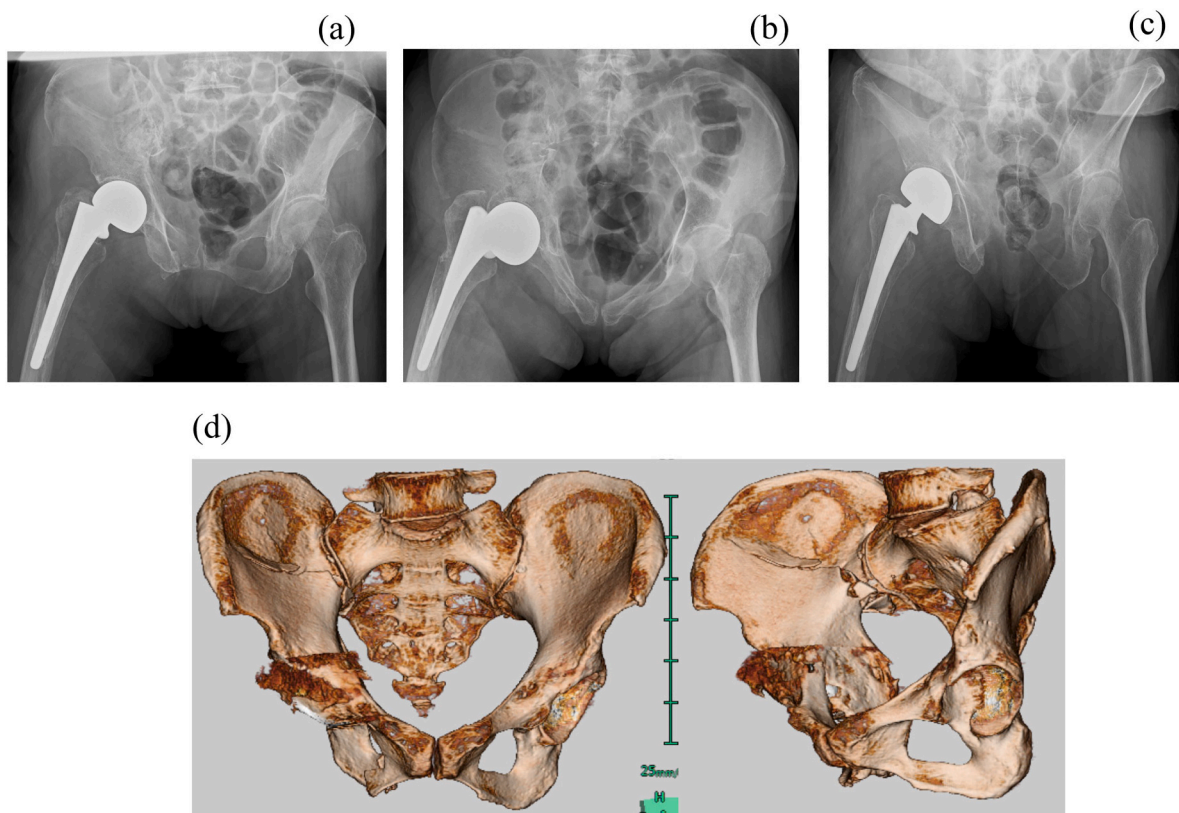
Representative pre-operative X-ray images taken during admission for fragility fracture of the pelvic ring. (a) Pre-operative pelvic anteroposterior view. (b) Pre-operative pelvic inlet view. (c) Pre-operative pelvic outlet view. (d) Pre-operative 3D-CT.
